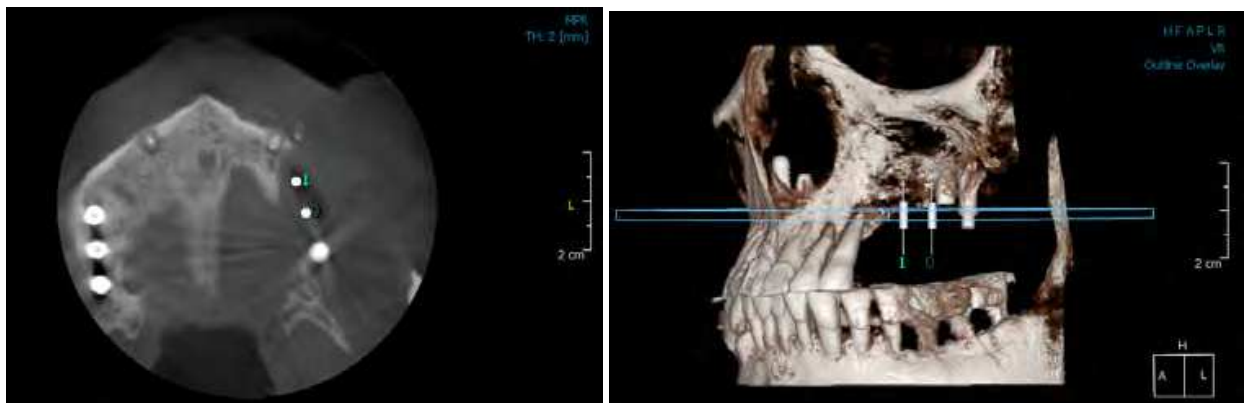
Virtual Imaging of Implant Installation (AZ-3000 CT, ASAHI)
